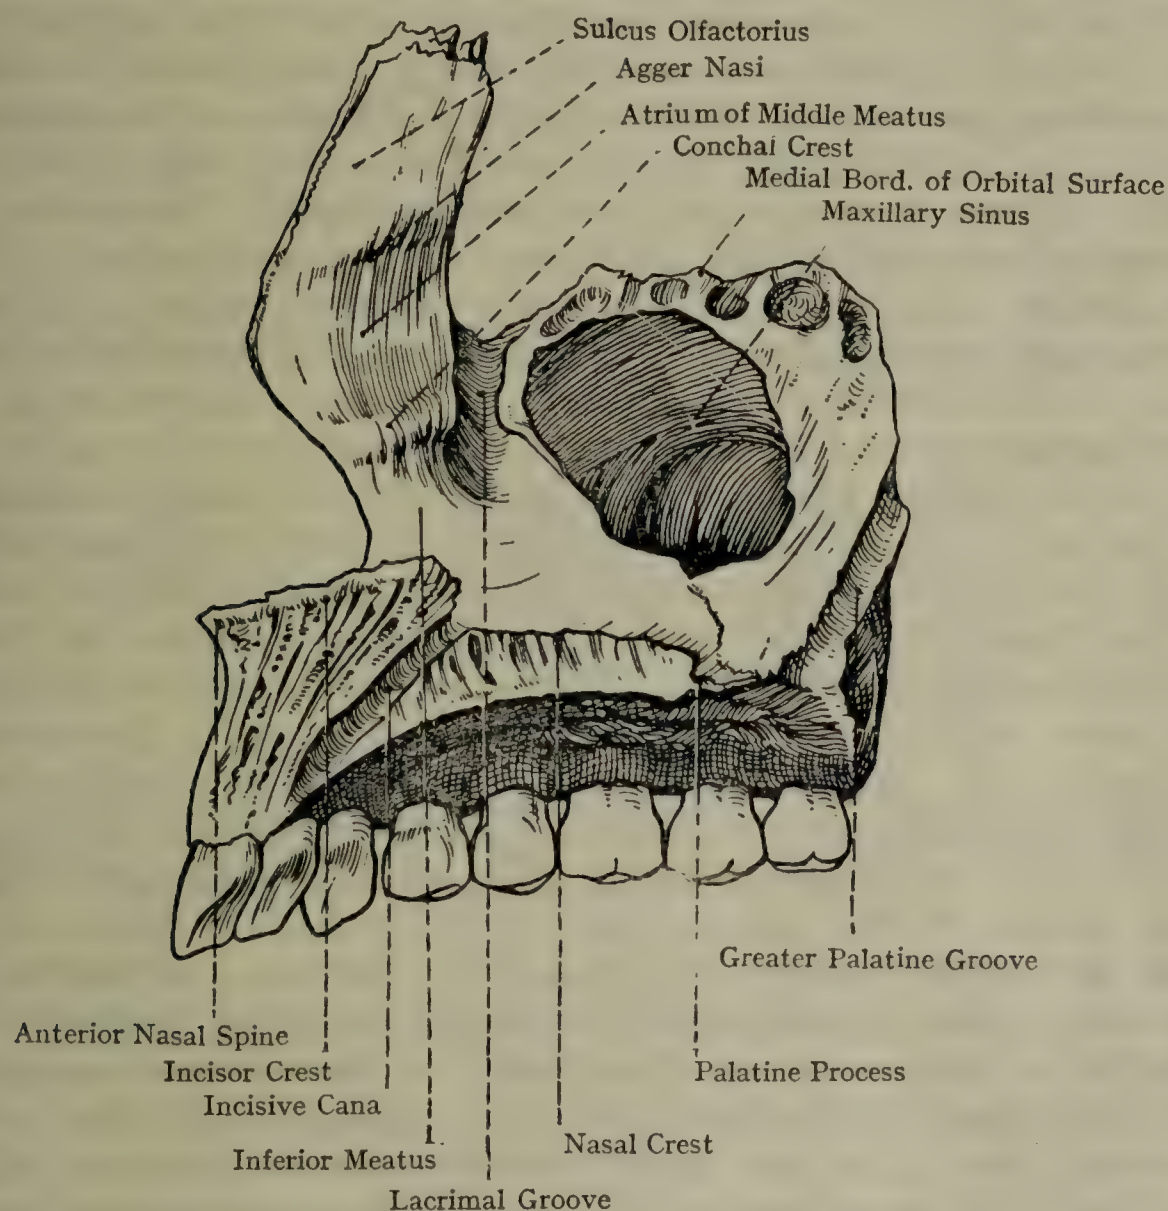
THE RIGHT MAXILLA (MEDIAL ASPECT).
